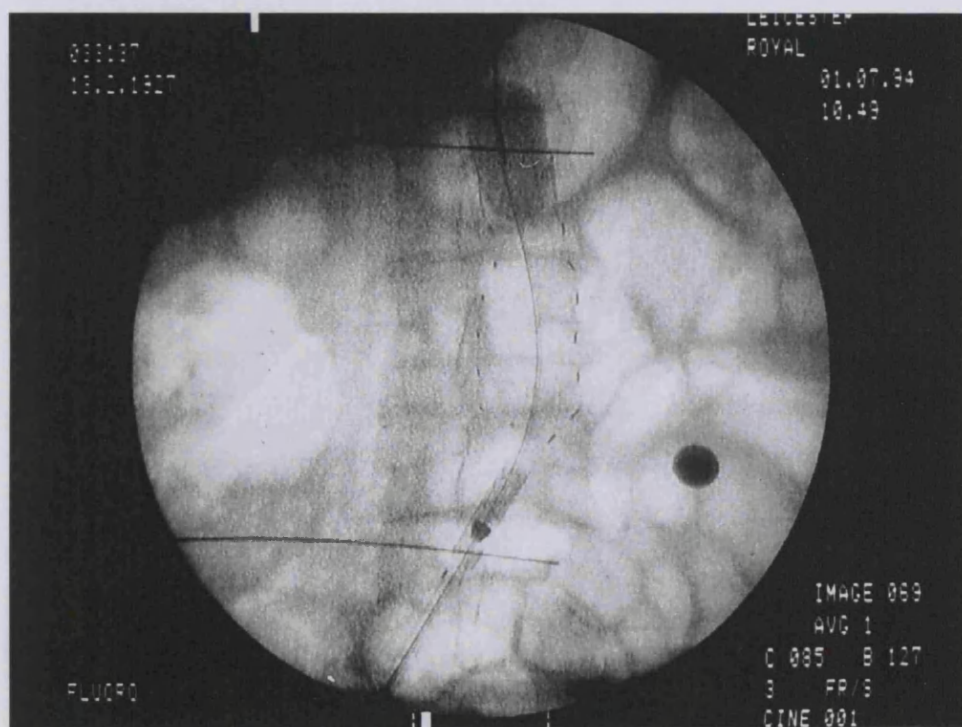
Radiographic image showing the deployment of the proximal attachment system, aided by balloon inflation. Note the radio-opaque markers positioned at the level of proximal and distal aortic cuffs.
